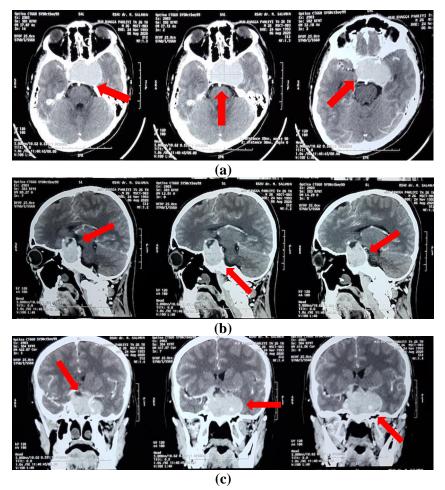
Brain CT-Scan with contrast showed enhancing mass. (a) axial plane showed homogen mass at sella tursica with size 50mmn x 30mm (red arrow). (b) sagittal plane showed homogem mass located at intra sellar to suprasellar (red arrow) and cyctic multiple component at cranial side. (c) coronal plane showed homogen mass (red arrow) at intra sellar to suprasella and cyctic multiple component at cranial side.
